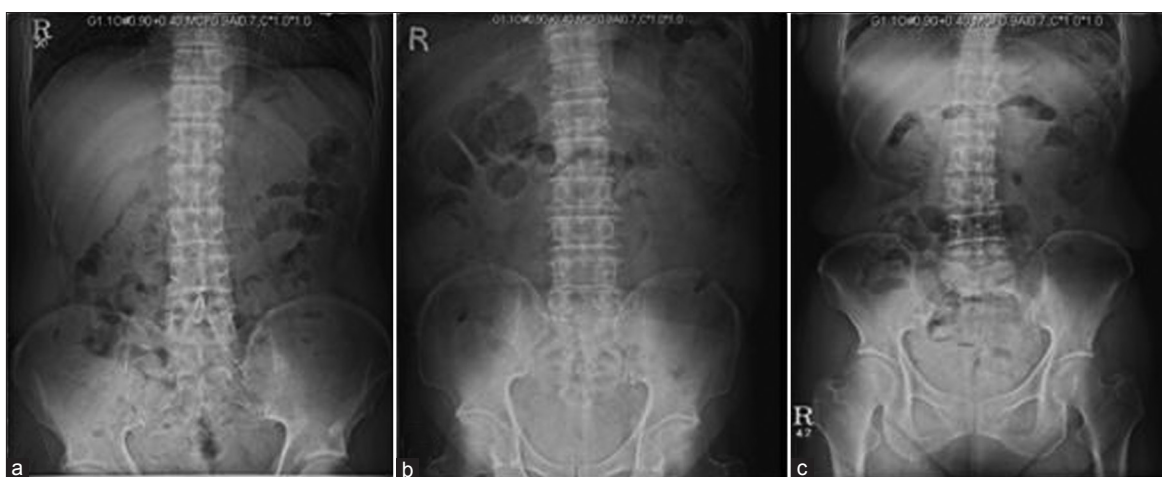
KUB lumbar spine AP and radiographic grades. (a) Acetabulum visualization: Entire (partial) acetabula are visible. (b) Hip joint visualization: Entire acetabula and femoral head areas are visible. (c) Femoral neck including lesser trochanter visualization: Entire hip joints including femoral necks and lesser trochanter areas are visible
